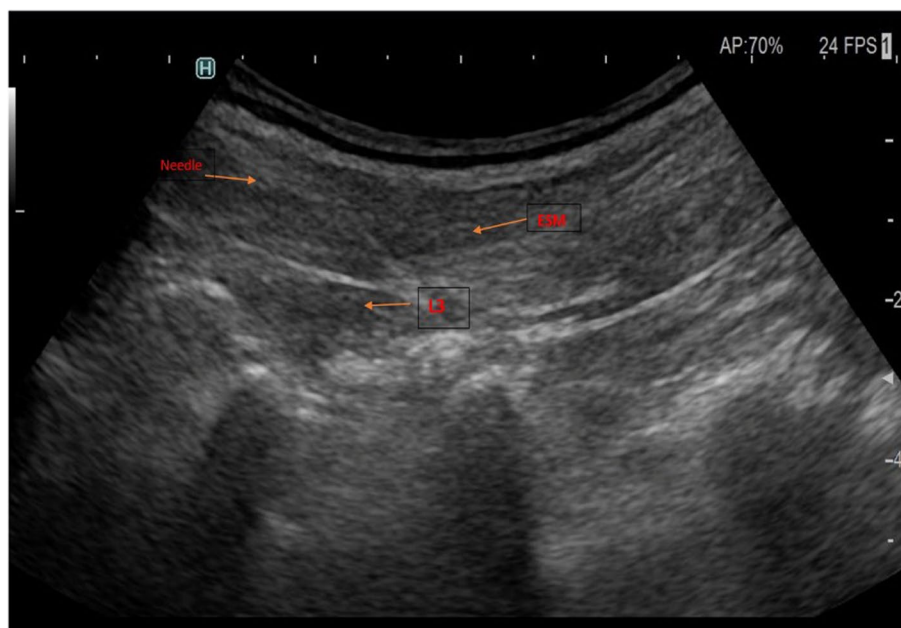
ESP block performed via ultrasonication guidance
